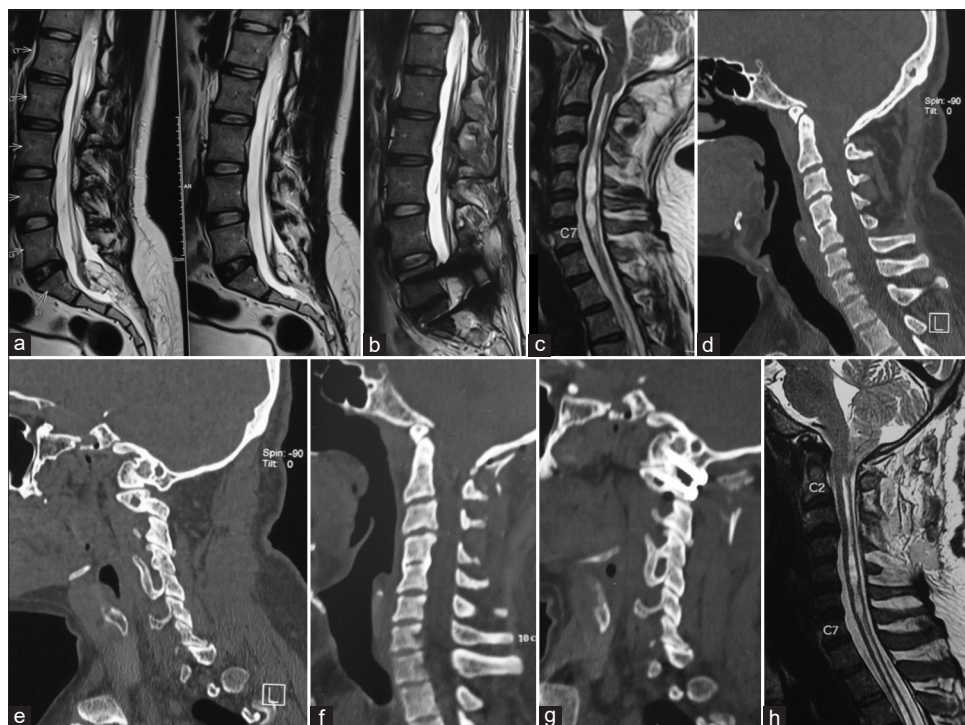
(a) T2-weighted magnetic resonance imaging showing tethered and low-lying spinal cord related to sacral lipoma. (b) Postoperative scan after detethering of cord and lumbosacral stabilization. (c) T2-weighted magnetic resonance imaging showing basilar invagination, Chiari malformation, and syringomyelia. (d) Computed tomography scan showing basilar invagination. (e) Computed tomography scan with the cut passing through the facets showing assimilation of the atlas. (f) Postoperative computed tomography scan. (g) Postoperative computed tomography scan with the cut passing through the facets showing the implant. (h) Postoperative T2-weighted magnetic resonance imaging (3 months after surgery) showing reduction of the size of the syrinx
